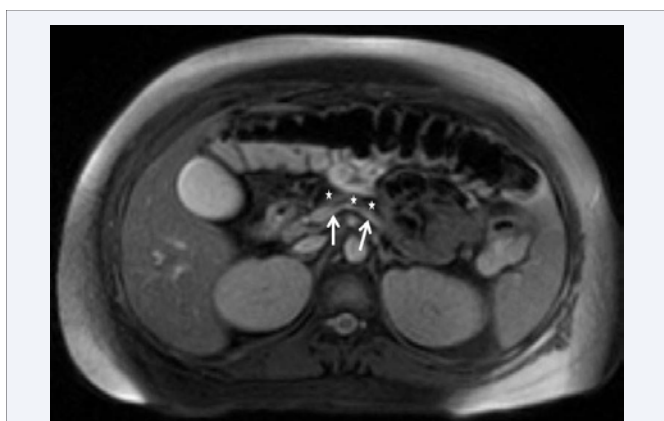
Axial MRI image demonstrates minimal to no pancreatic tissue in the expected location of the pancreas (stars) anterior to the splenic vein (arrows).
